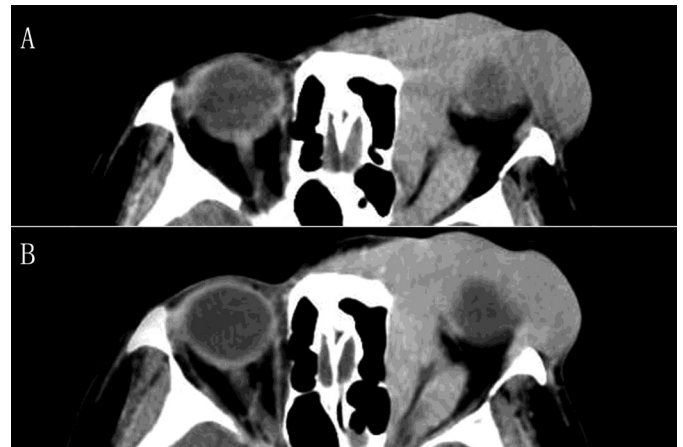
(A-B): A diffuse lymphoma of the left orbit on computed tomography films. A diffuse, isodense soft-tissue mass is shown in the upper quadrant of the left orbit (A). The lesion progresses along the orbital wall "casting sign". The left eyeball proptosis and superior rectus muscle thickening can be observed simultaneously. The mass displays homogeneously marked enhancement on computed tomography examination with IV contrast (B).
